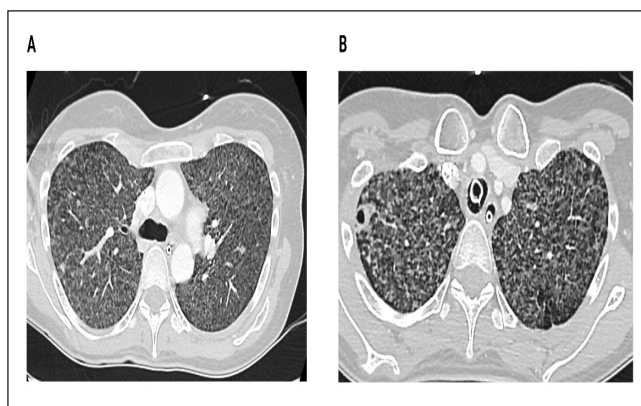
Contrast-Enhanced Chest Computed Tomography. T2 Lung axial view. Centrilobular micronodules with linear branching pattern (Tree-in-bud sign) and multiple heterogeneous spiculated soft-tissue nodules involving both lungs more prominent in the apical regions of both with the presence of a pulmonary cavitation.
